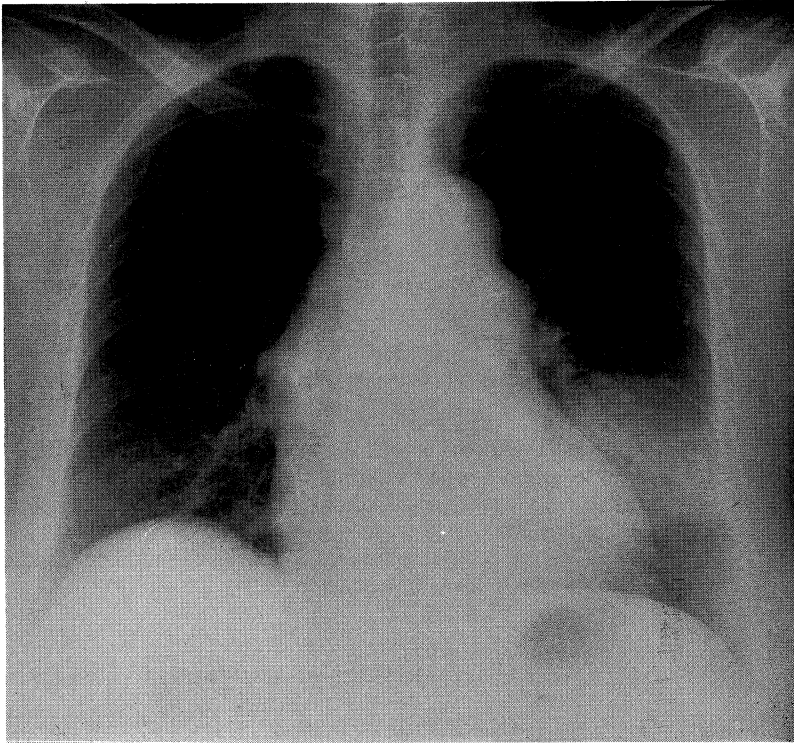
A chest radiograph showed a large abnormal shadow in the lower lobe of the left lung.
